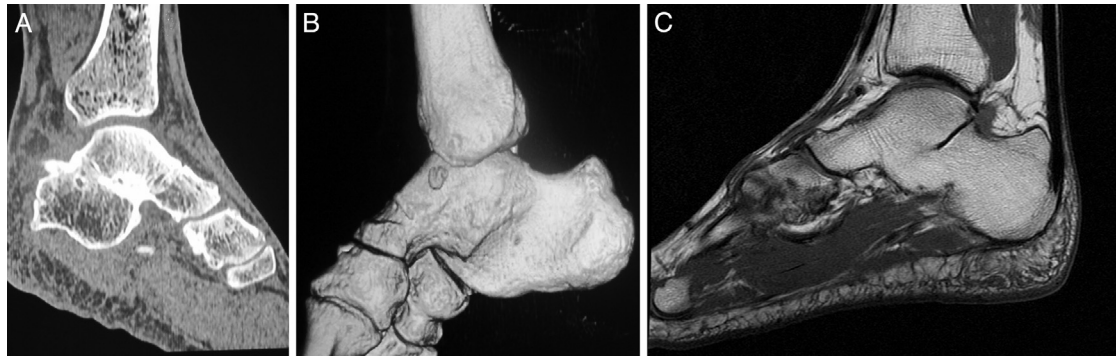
Talocalcaneonavicular coalition seen on (A) computed tomography scan, (B) 3-dimensional computed tomography scan, and (C) magnetic resonance imaging scan.
